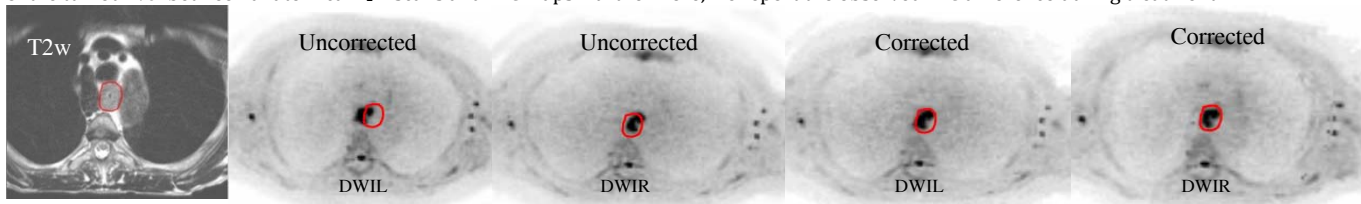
Original DWI scans and geometrically corrected DWI scans (both $b = 800 \text{ s/mm}^2$, with phase encoding direction left of right), together with a T2W scan. Delineation was based on the T2W scan. In the original DWI scan a clear shift and deformation of the diffusion restricted area can be observed. After correction, the diffusion restricted area in DWIL and DWIR are comparable and coincide with the location of the delineation.
